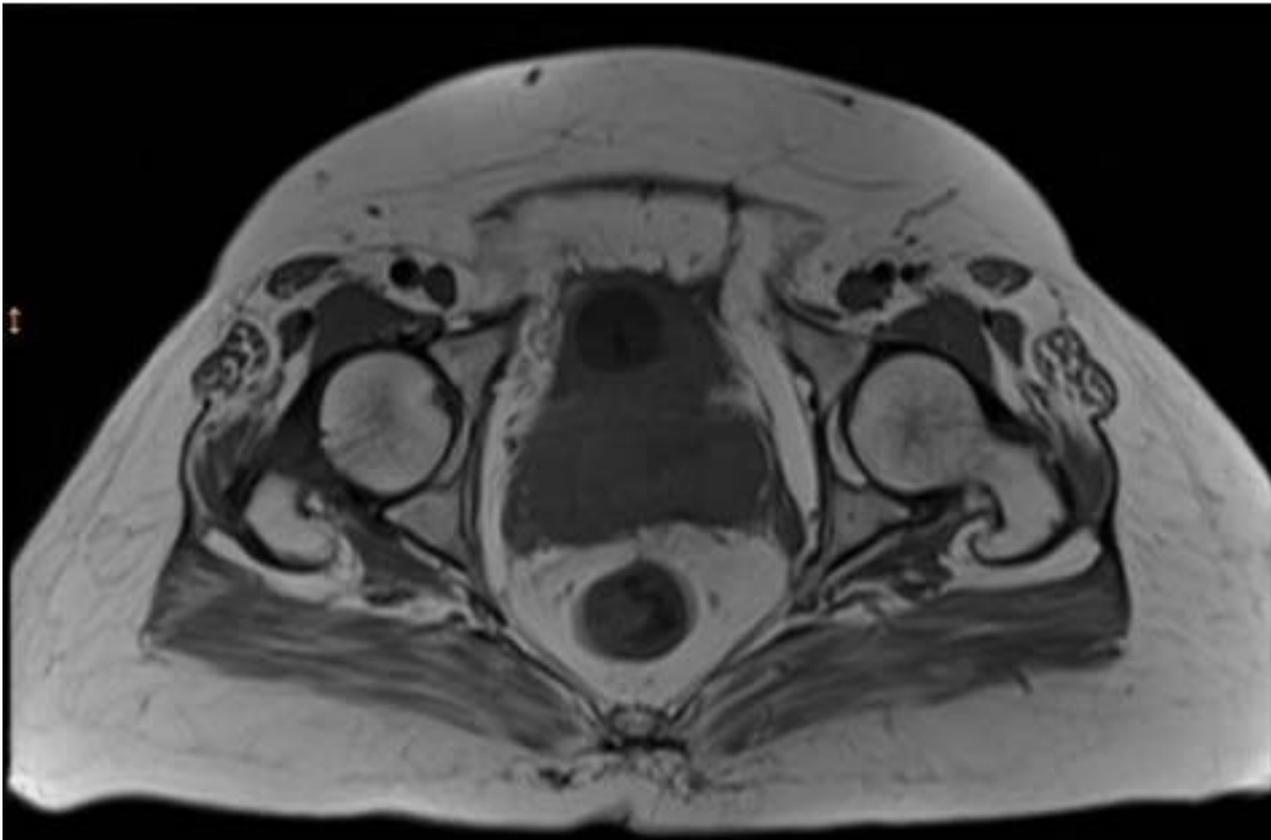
Pelvic MRI revealed a 7x7.5 centimeters mass lesion in the uterine cervix
